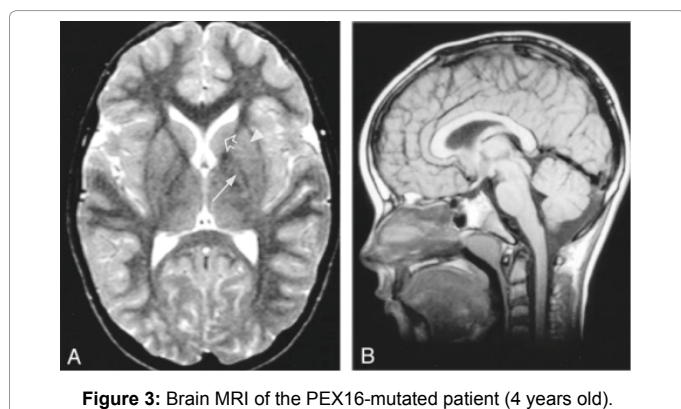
Brain MRI of the PEX16-mutated patient (4 years old).
